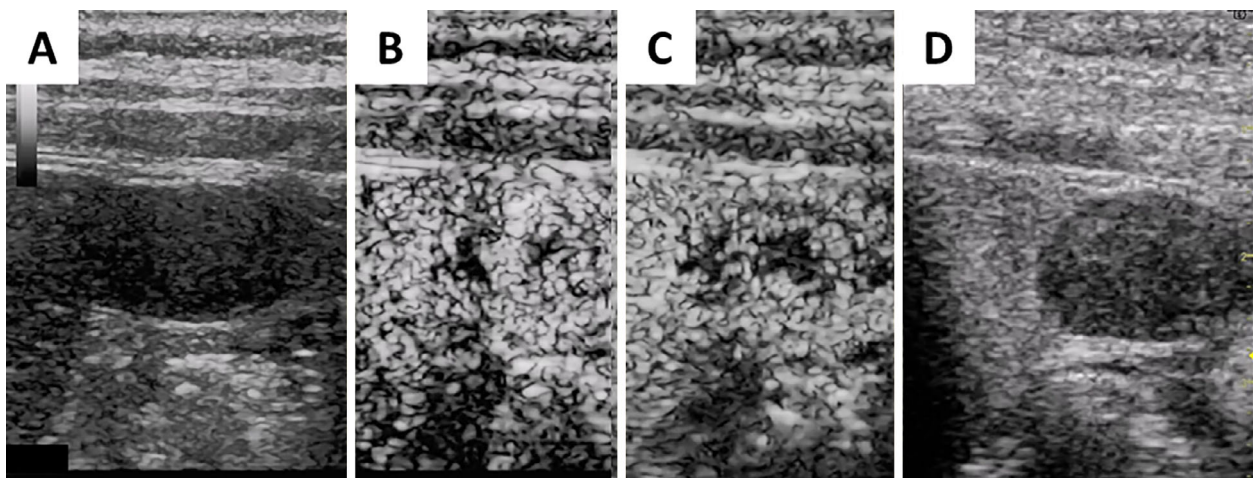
Before intravenous bolus, the tumor was revealed to be a uniformly low-echoic and irregularly shaped projecting mass (A). Contrast-enhanced ultrasonography (Sonazoid®) showed that the tumor with hyper enhancement did not have a basket pattern at the arterial phase (B), with some areas of the tumor being washed out in the portal vein phase (C). Sonazoid-enhanced ultrasonography also showed uniform hypoenhancement in the tumor at the post-vascular phase (D).
